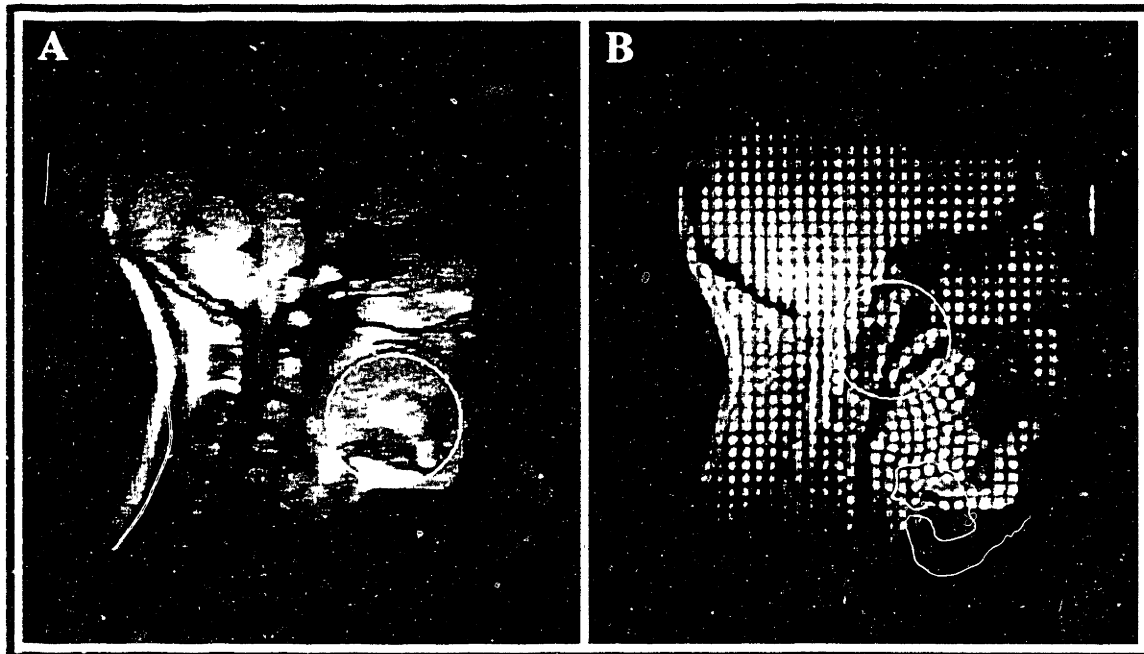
The initial (A) and final (B) tongue curvatures were measured by fitting a circle to a portion of the tongue (10 mm) that approximates the contour of the tongue-tongue-stomach interface. The best fit circle was determined by minimizing the mean square error between the circle and the MRI image, using a very fine grid (1000 points).
